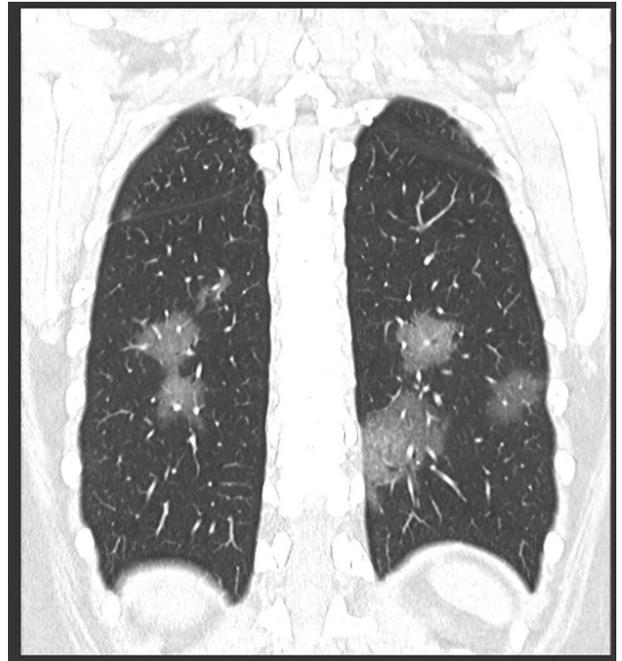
Axial (A) and coronal (B) image of a typical CT appearance for COVID-19, both readers agreed.
